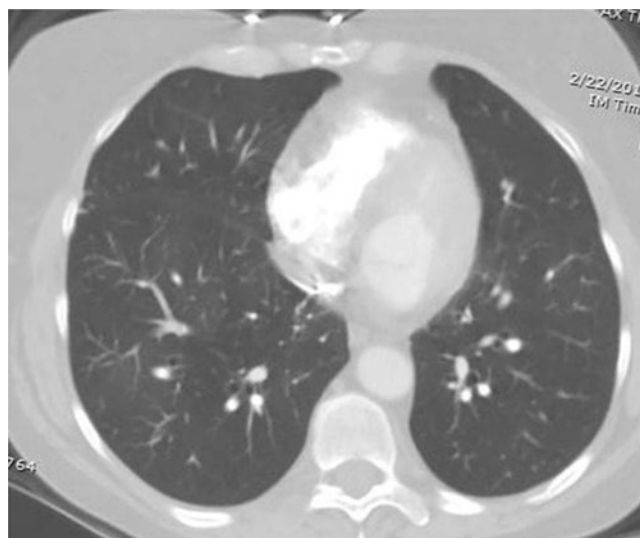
Constrictive bronchiolitis. Chest CT scan demonstrating bilateral mosaic attenuation and air trapping
